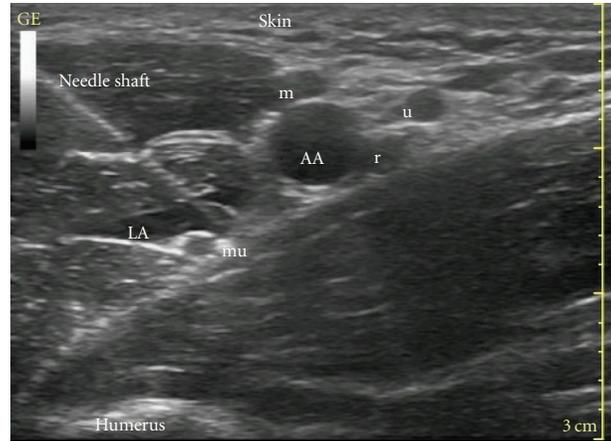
Ultrasound scan of axilla. AA: axillary artery, LA: local anaesthetics, r: radial nerve, mu: musculocutaneous nerve, m: median nerve, and u: ulnar nerve. This is an in-plane approach, with the whole length of the needle shaft visible under ultrasound.
